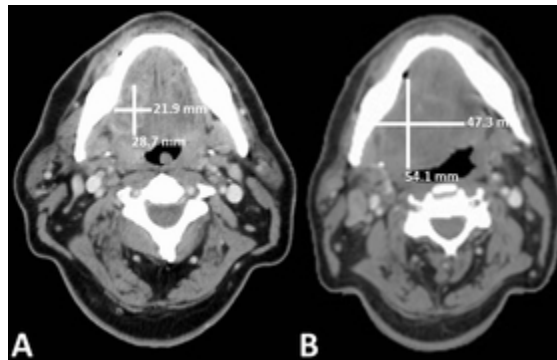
Tumour growth assessment using maximal orthogonal tumour diameters from axial contrast enhanced diagnostic CT scans (A) and subsequent planning CT scans (B) Axial contrast enhanced diagnostic CT scan (A) and subsequent planning CT scan (B) 46 days later of a cT4a cN2b cM0 squamous cell carcinoma of the oral cavity. The maximum anterior-posterior and medio-lateral tumour diameters (white lines) were measured from axial scans, the cranio-caudal tumour diameters were measured from corresponding coronal scans (not depicted). The tumour volume was assessed as previously described using an ellipsoid formula⁹. PT-volume from diagnostic CT was 14.8mL, PT-volume from planning CT was 51.0mL translating to a PT-SGR of 2.8%/day.
